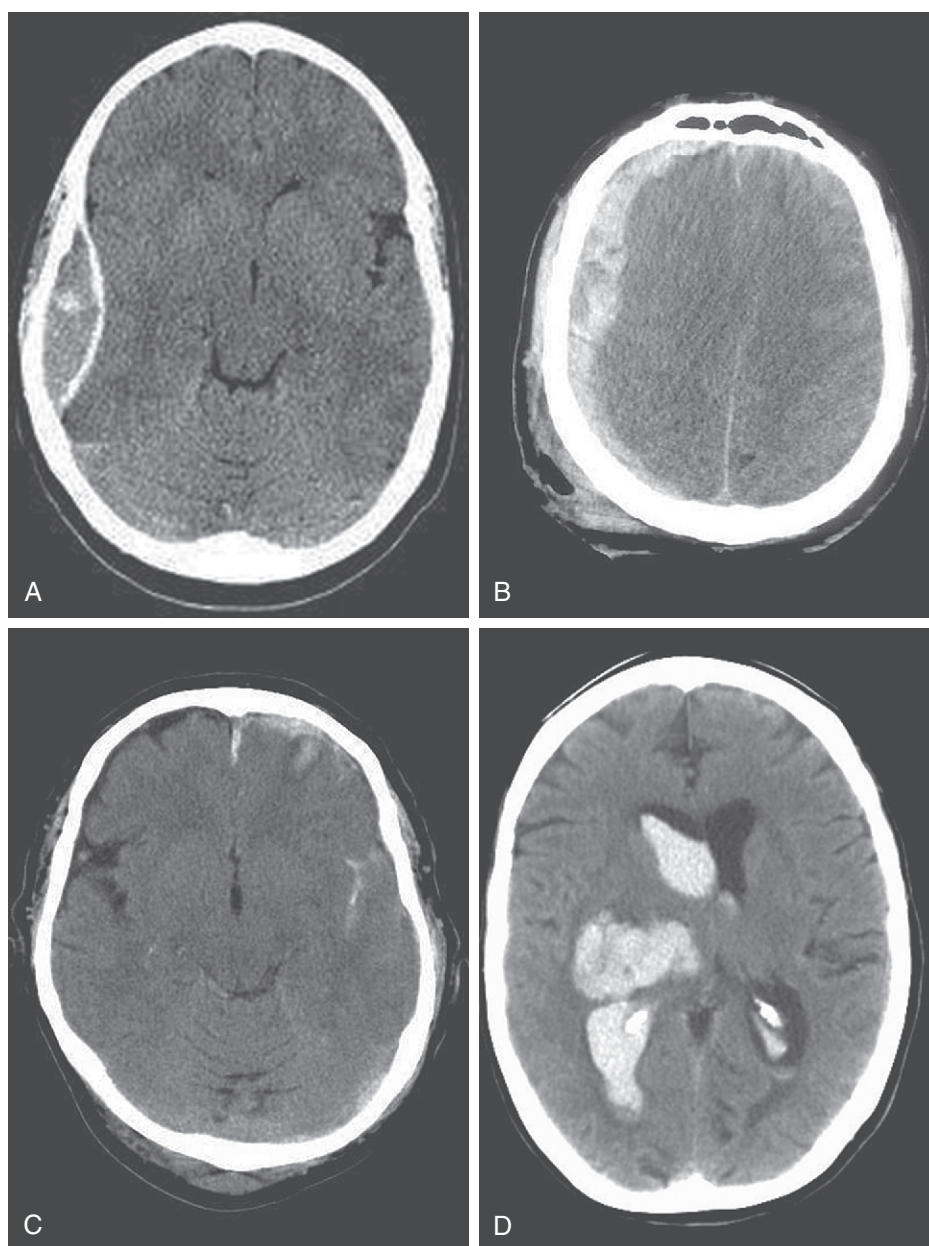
Computed tomography scans of intracranial hemorrhage. A, Epidural hematoma; B, subdural hematoma; C, subarachnoid hematoma; D, intracerebral hematoma. (From DeLee JC, Drez D, Miller MD: *DeLee and Drez's Orthopaedic Sports Medicine*, 3rd ed. Philadelphia, Saunders, 2009.)
